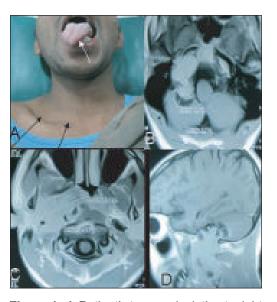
A-Patient's tongue deviation to right (white arrow) with atrophy of sternomastoid and trapezius (black arrows). Preoperative MRI of brain and neck (Case 1) T1W images; B & C: axial sections showing tumor in posterior fossa and jugular foramen. D: saggital section showing jugular foramen tumor extending from posterior fossa to neck.
